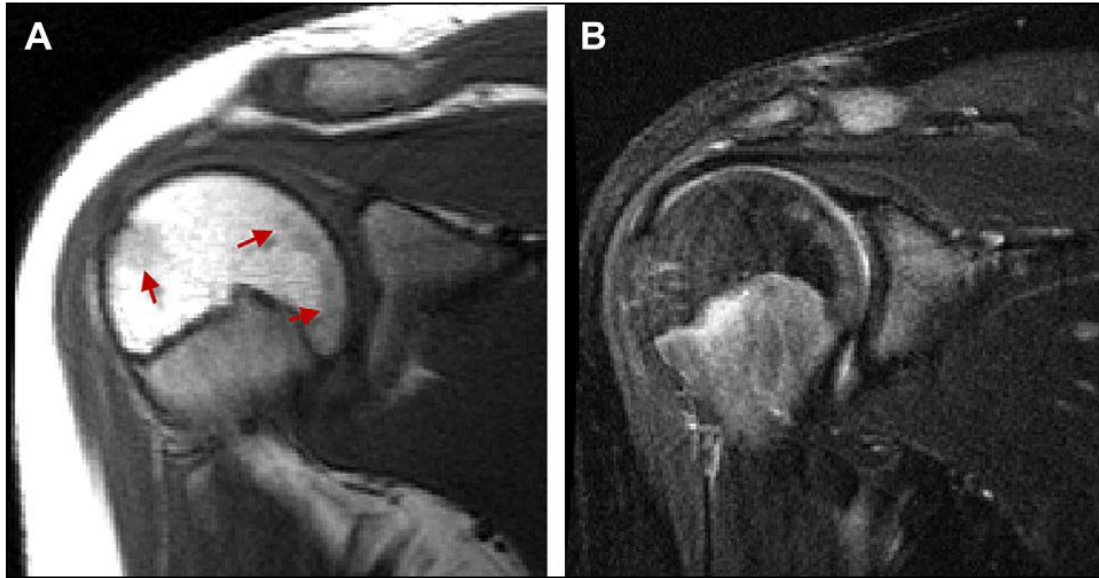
Foci of normal hematopoietic marrow are present within the proximal humeral epiphysis especially in the subchondral region as shown on T1-weighted (A, arrowheads) and T2-weighted fast spin echo sequence (B) (*Quoted from Hwang and Panicek, 2007*).
